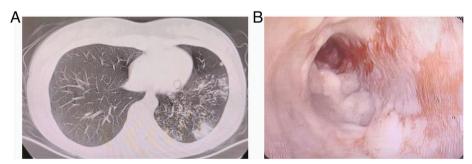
Chest CT images of case 1. Multiple patchy infiltrations, nodules, segmental solid shadows in the left upper lobe of the lung. Diffuse distribution of spots and chestnut grain shadows in both lungs (A). Left main bronchus mucosal hyperemia, lumen stenosis, left upper lobe and lower lobe openings narrow, mucosal erosion a little necrosis (B)
